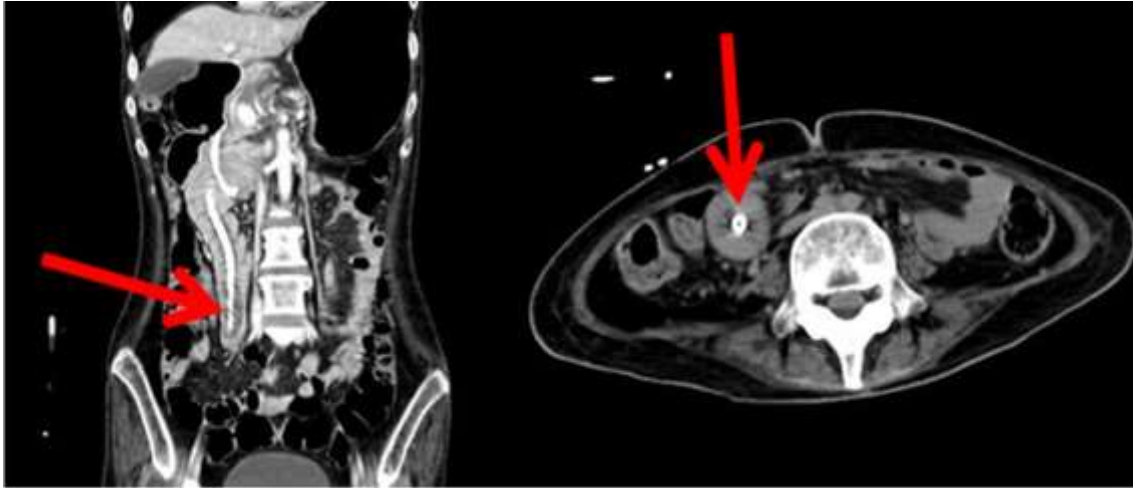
CT abdomen images of duodenal intussusception by the PRG tube
